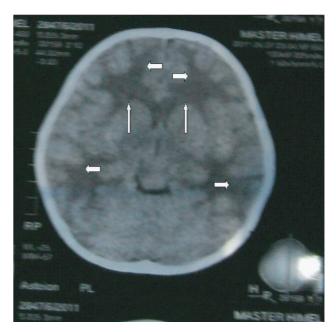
CT scan revealed diffuse hypodensity in the subcortical white matter (small arrows) and periventricular white matter (long arrows) without perilesional edema
